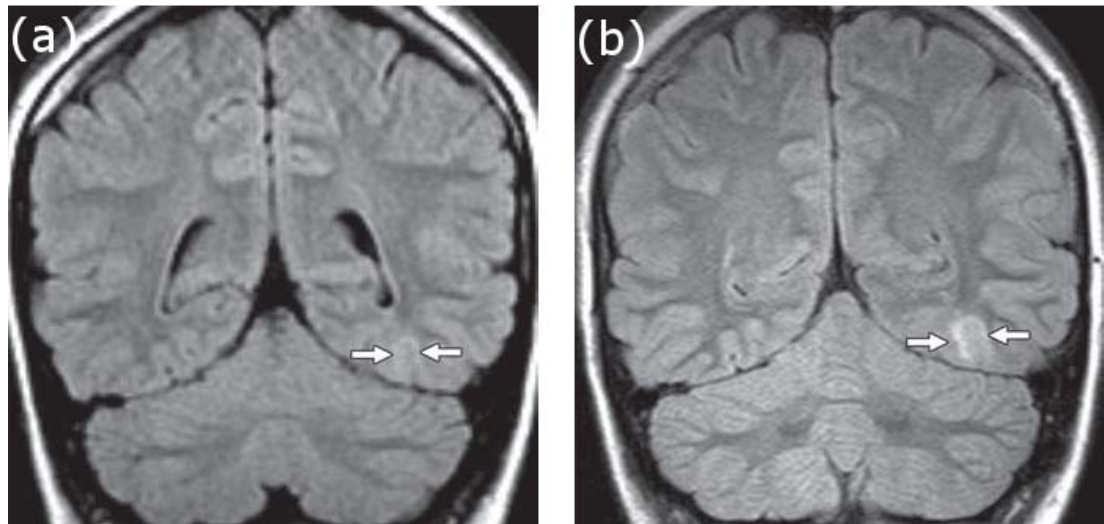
MRI scans of patient with intractable nocturnal seizures. (a) Coronal image using 1.5-T magnet MRI showing questionable curvilinear focus of high signal intensity (arrows). Abnormal signal intensity was missed at first review of images. (b) Coronal image using 3-T MRI showing curvilinear band of high signal intensity (arrows) white matter without apparent mass effect. (Reproduced from (Phal et al., 2008))
